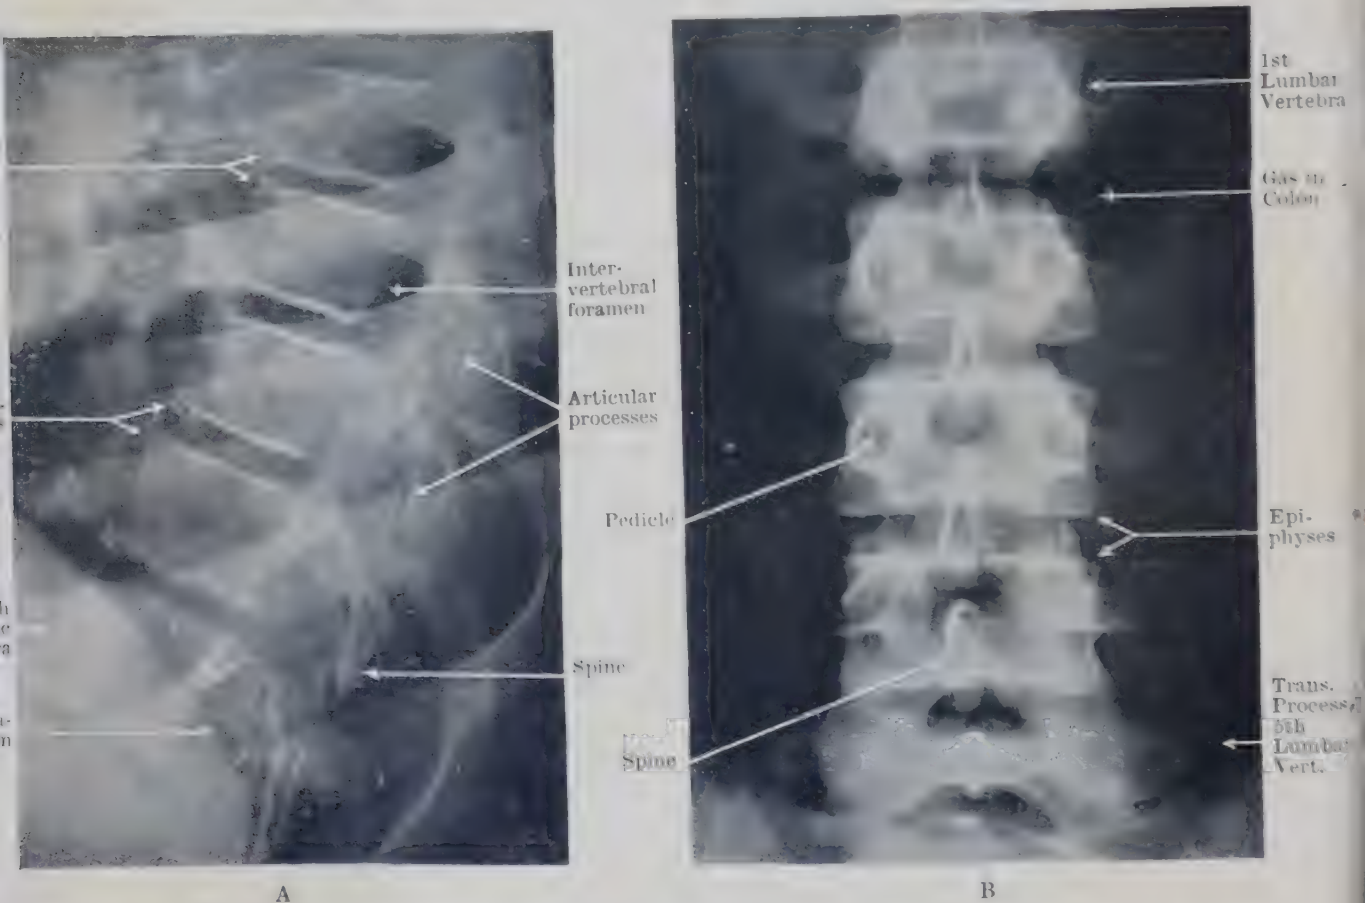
RADIOGRAPHS OF (A) THORACIC AND (B) LUMBAR VERTEBRÆ OF A GIRL AGED 12, SHOWING THE EPIPHYSES OF THE VERTEBRAL BODIES.
